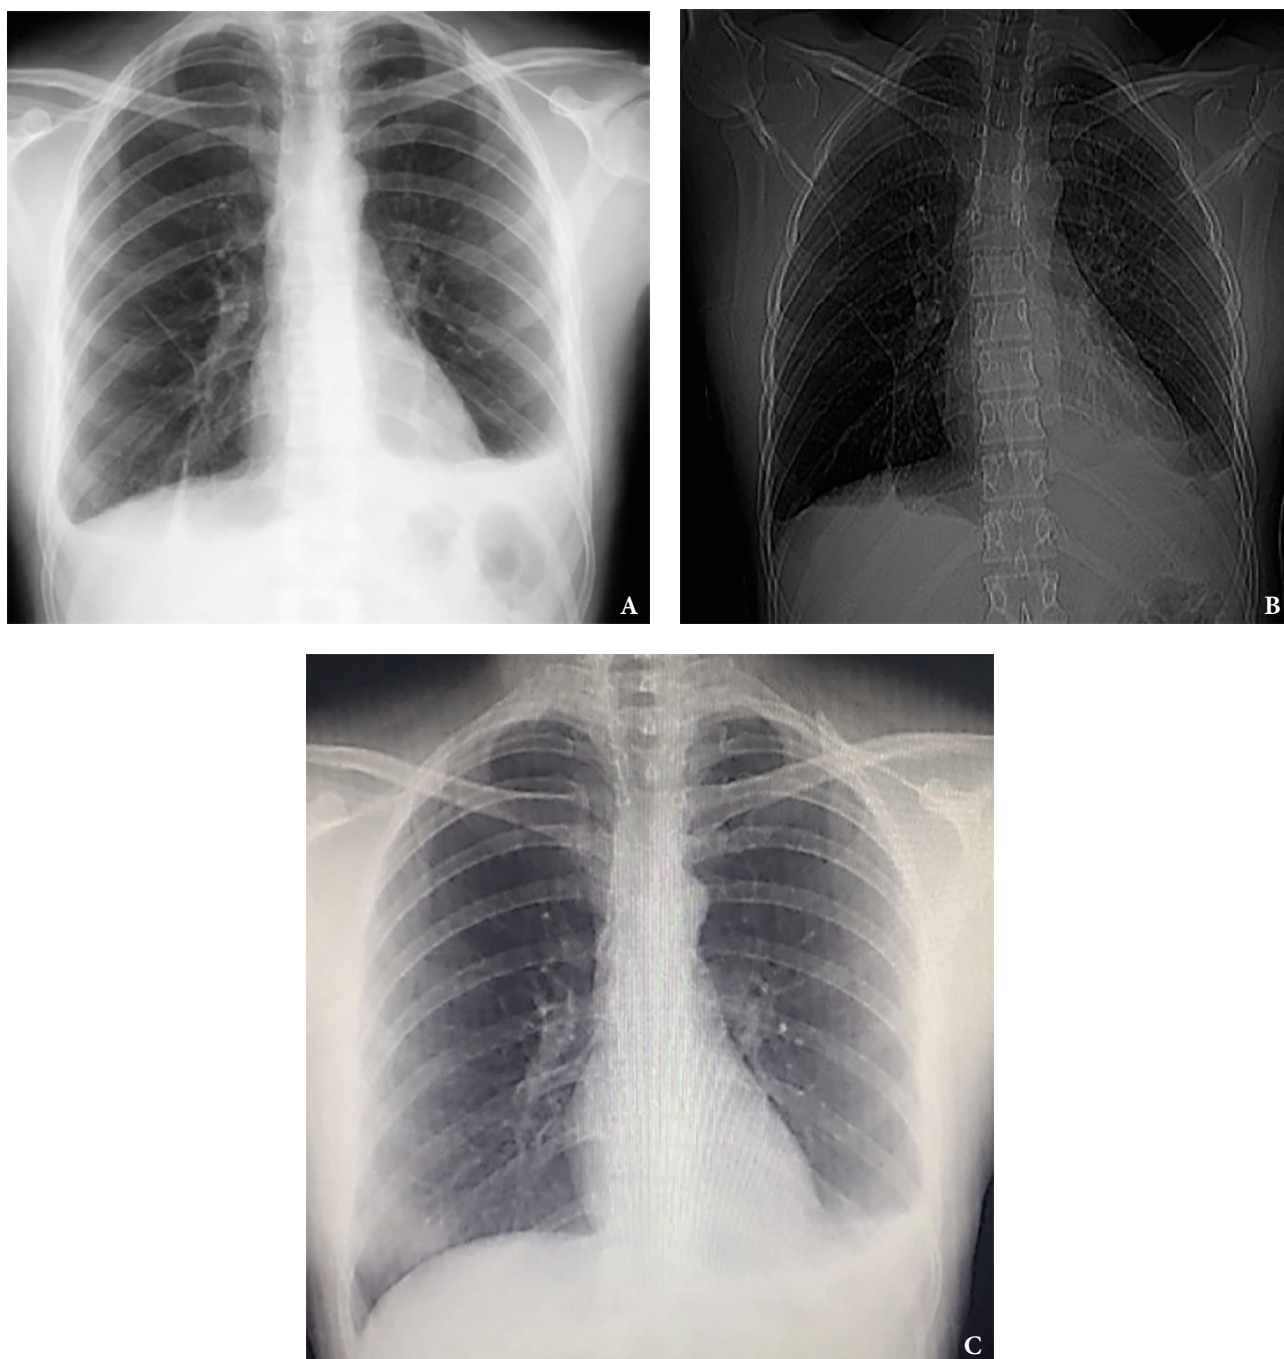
Chronologic follow-up (A, initial x-ray; B, x-ray upon treatment) of chest x-rays showing pleural effusion and its resolution 1 month post-op (C).
